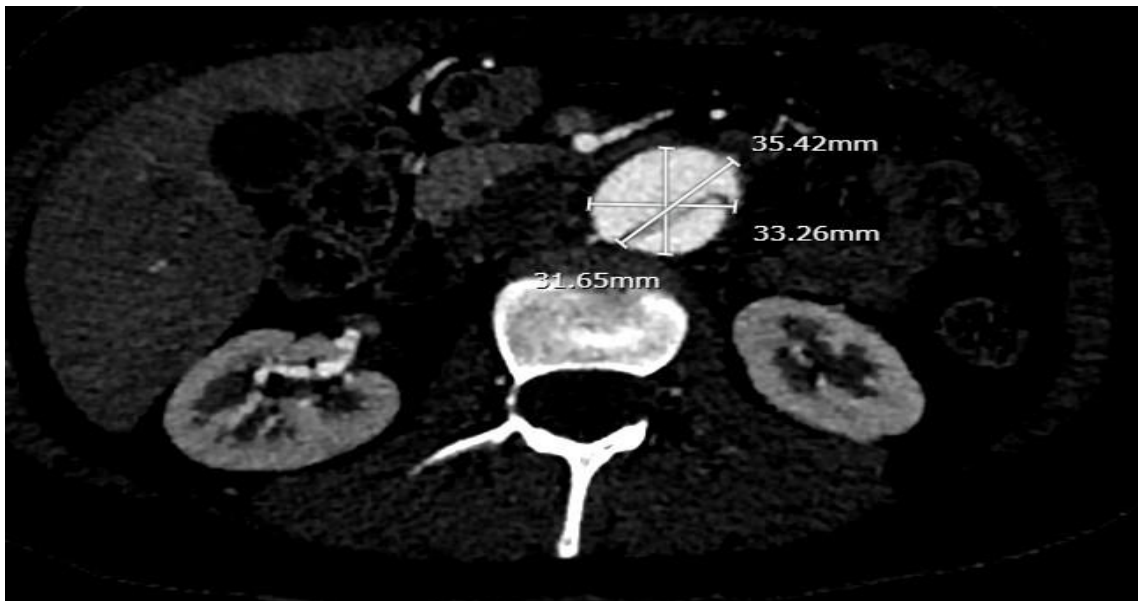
Axial CT Image of the Abdominal Aorta at the Level of the Renal Artery Origins, Demonstrating a Maximal Diameter of 3.5 Cm. The Right Renal Artery Arises From The Dissected Segment Of The Abdominal Aorta (False Lumen).
